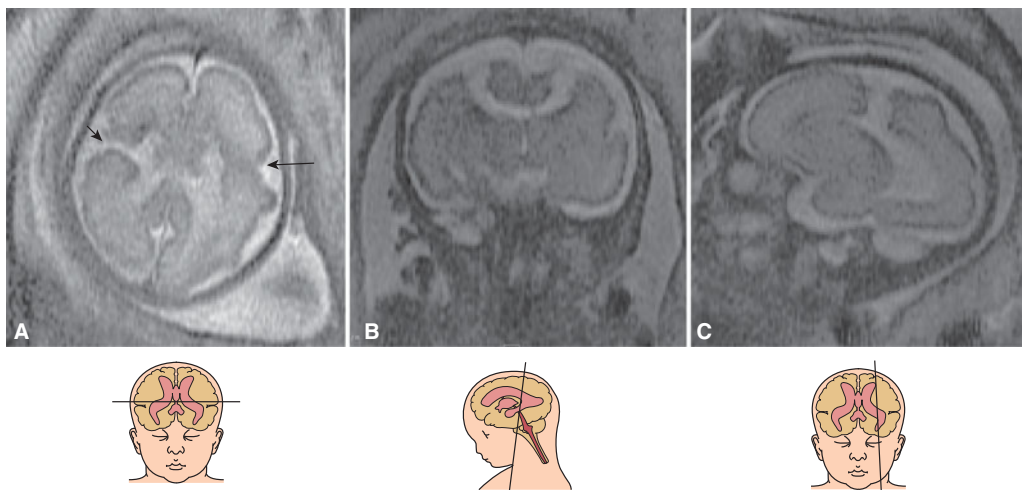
T2-weighted MRI at 28 postmenstrual weeks shows bilateral schizencephaly with multiple clefts lined by abnormal gray matter. (A) The axial section demonstrates the presence of an open lip (arrowhead) and a closed lip (arrow). Coronal (B) and sagittal (C) planes show open-lip defects lined with gray matter.
